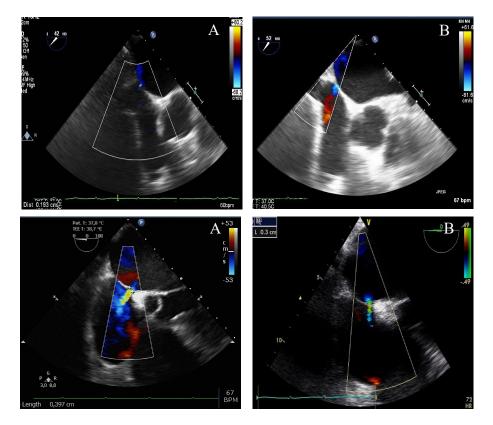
Persistent iatrogenic atrial septal defect with left-to-right shunt detected by transoesophageal echocardiography in a patient at 3-month (A) and 12-month (B) followup after radiofrequency (top) and cryoballoon (bottom) ablation. Electrophysiology Laboratory, Gottsegen National Cardiovascular Center
